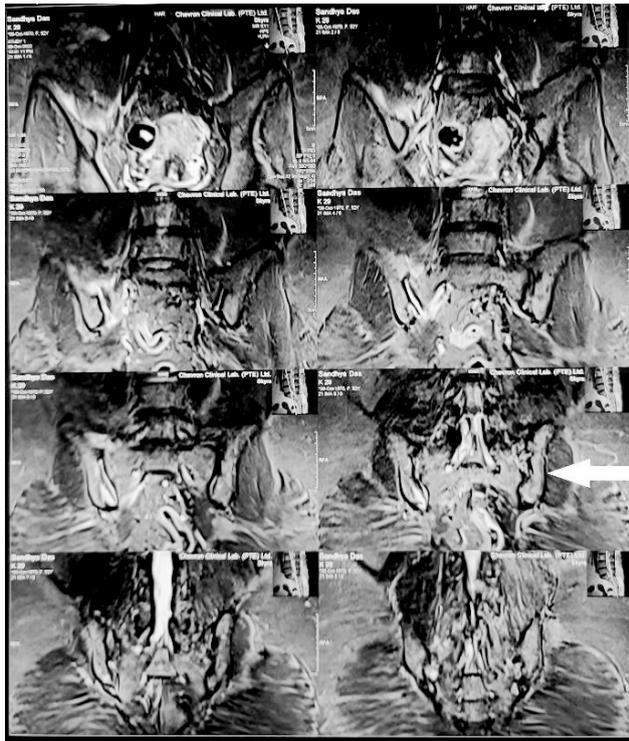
MRI of Hip Joint showing Sacroiliitis of Rt Hip Joint
